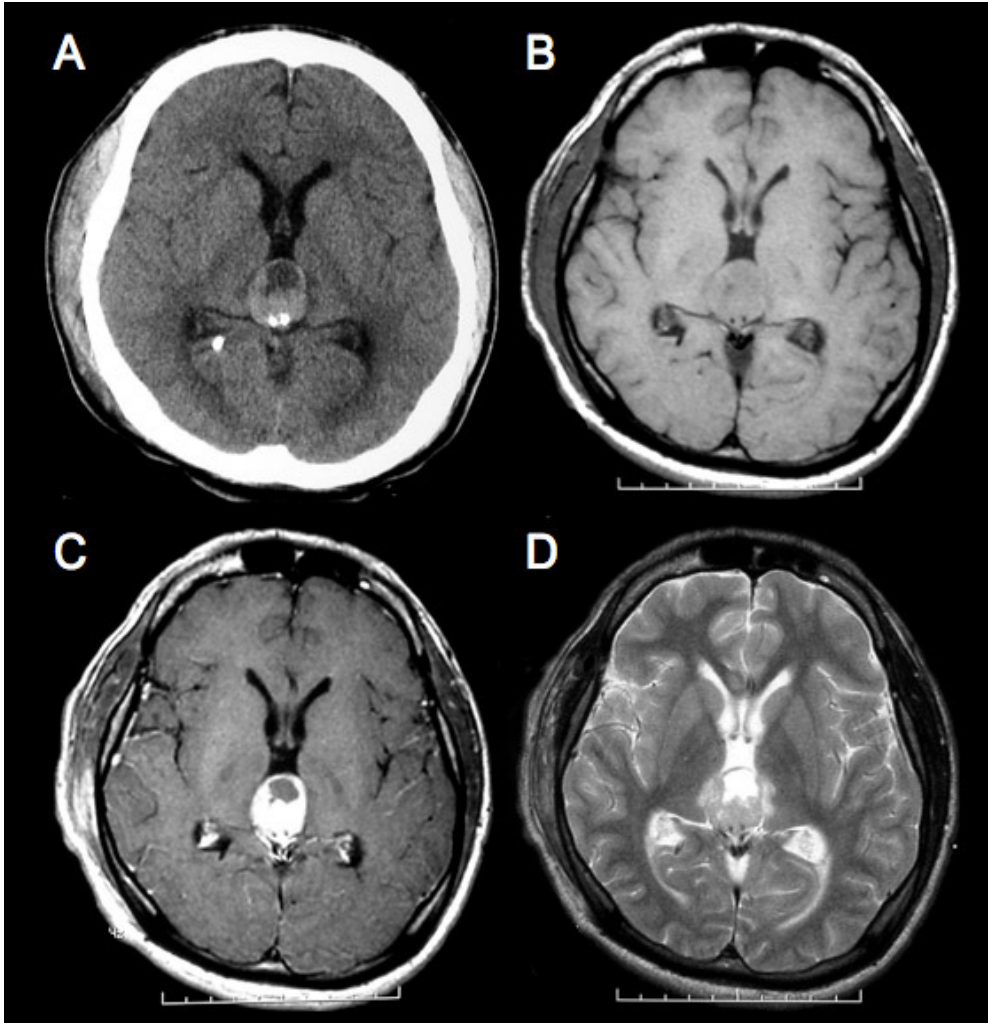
Pineal germinoma in an 18-year-old boy. (A) CT scan shows a slightly high-density mass in the pineal region, together with a cyst and some calcifications. A ventricular drainage tube is inserted into the posterior horn of the right lateral ventricle. The tumor shows slightly low signal intensity on the T1-weighted image (B) and slightly high signal intensity on the T2-weighted image (D). The tumor is homogeneously well enhanced by gadolinium (C).
